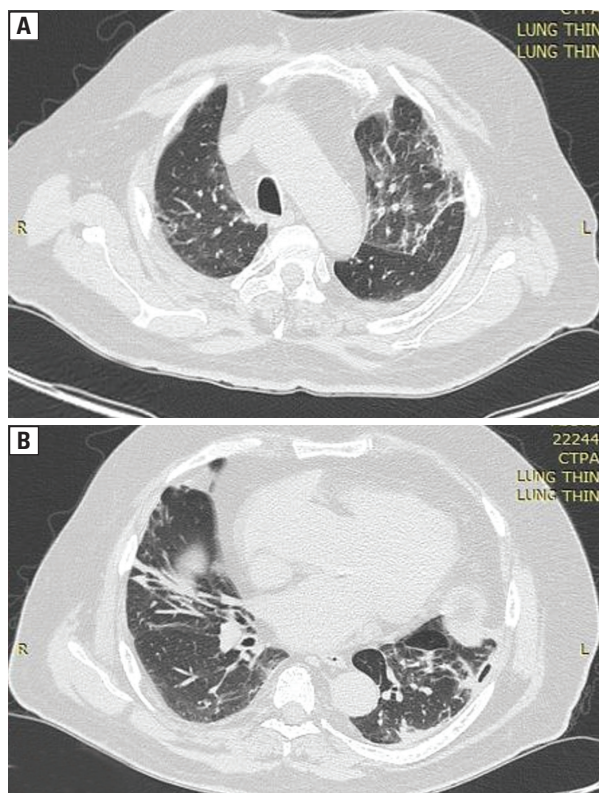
High resolution computed tomography of chest showing fibrotic opacities in bilateral upper lobes (left > right)
